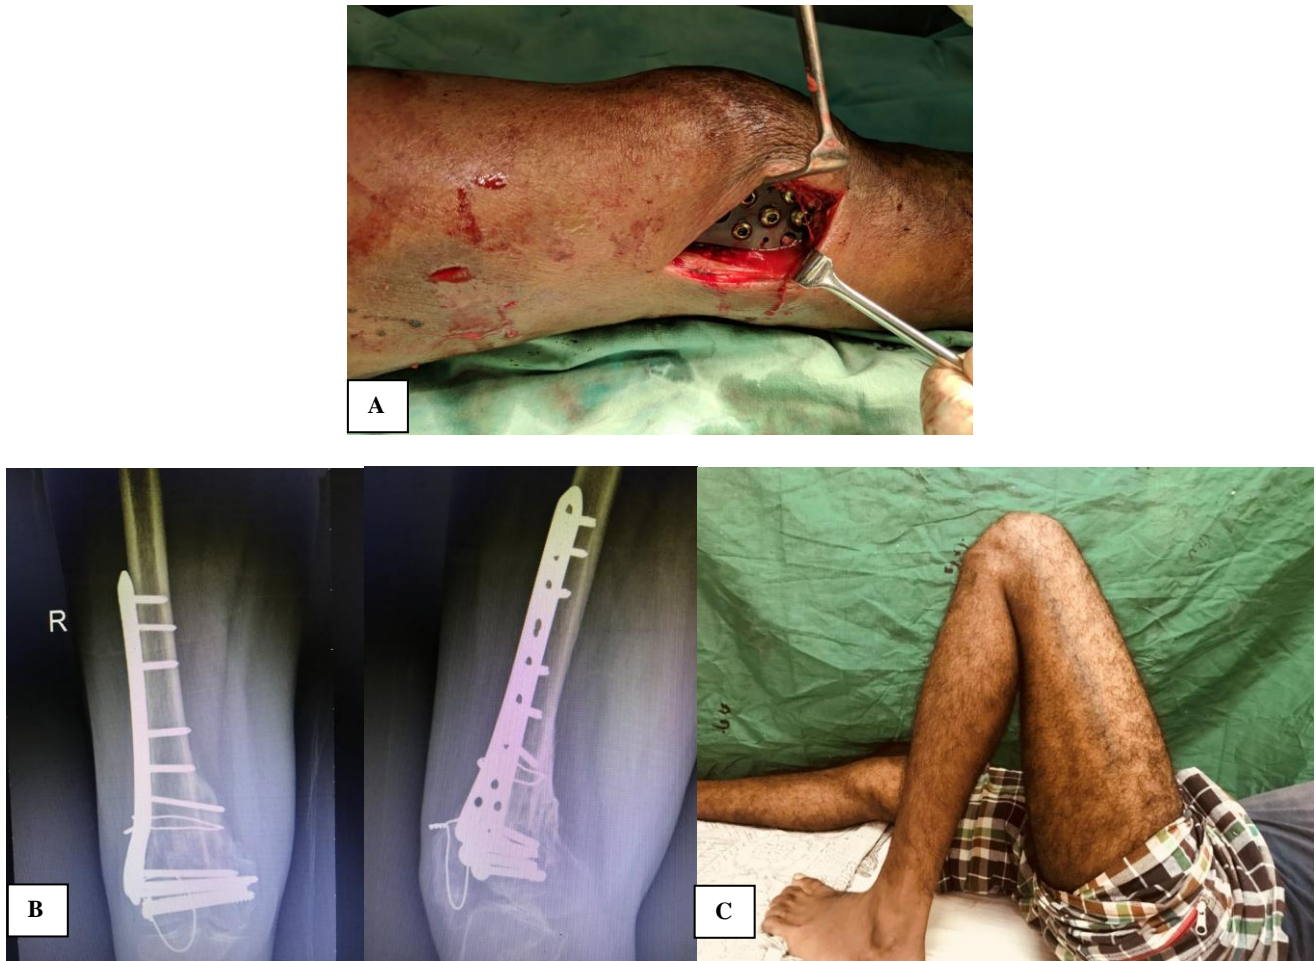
(A) Intraoperative image, (B) X-ray, 1 year follow-up, (C) functional outcome.
